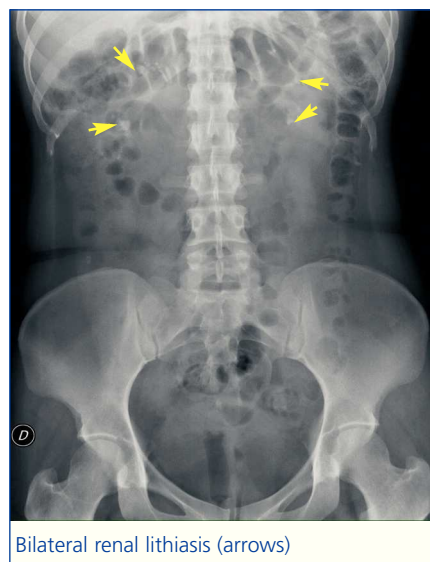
Simple abdominal x-ray.
